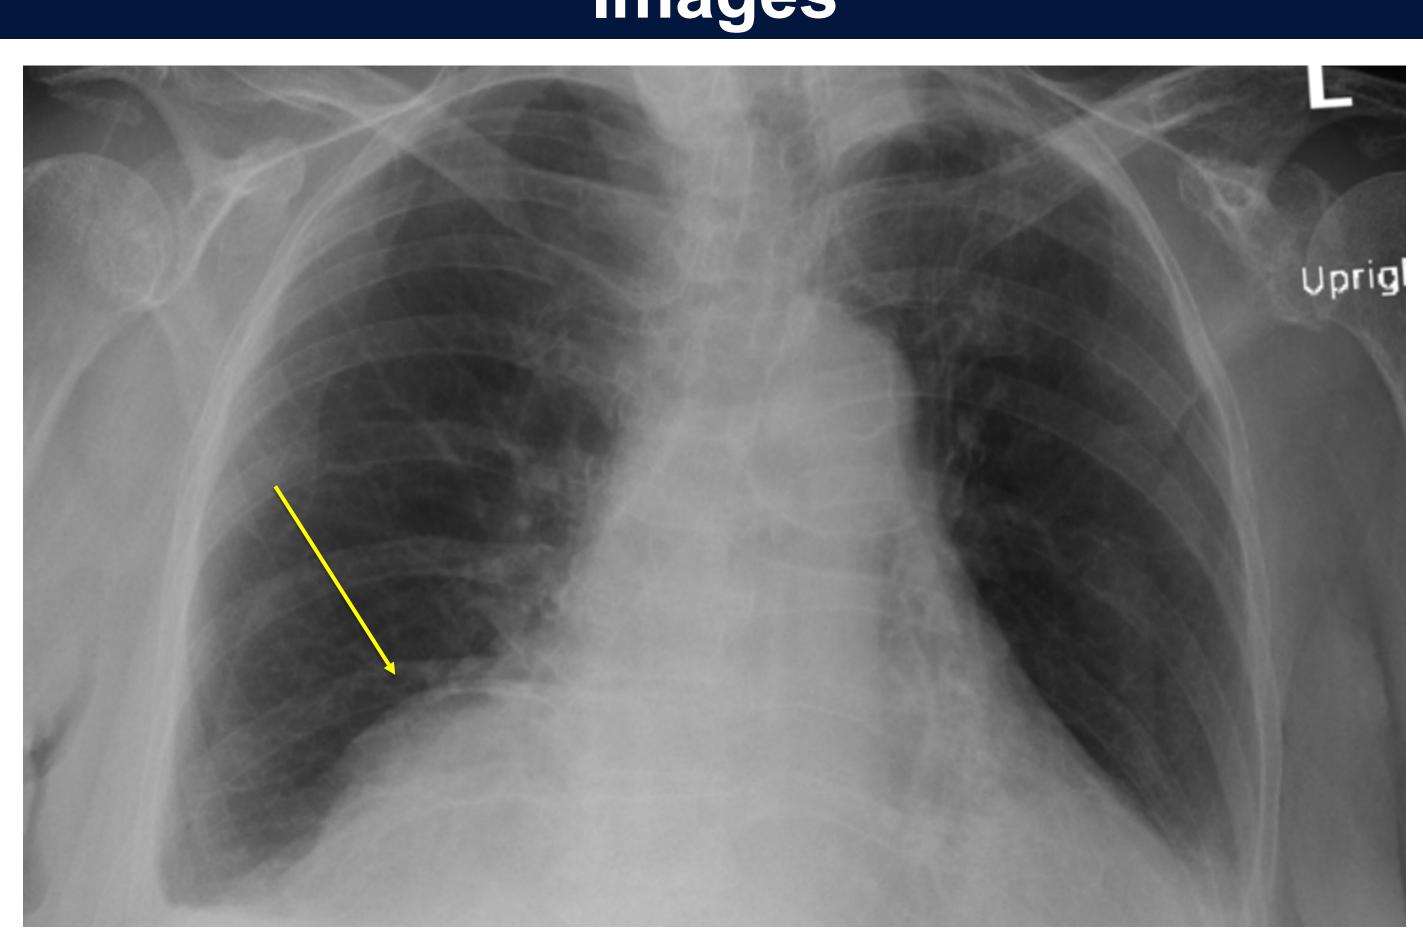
Chest X-ray showing a 6mm mass-like abnormality along the right cardiac border and small right pleural effusion.
